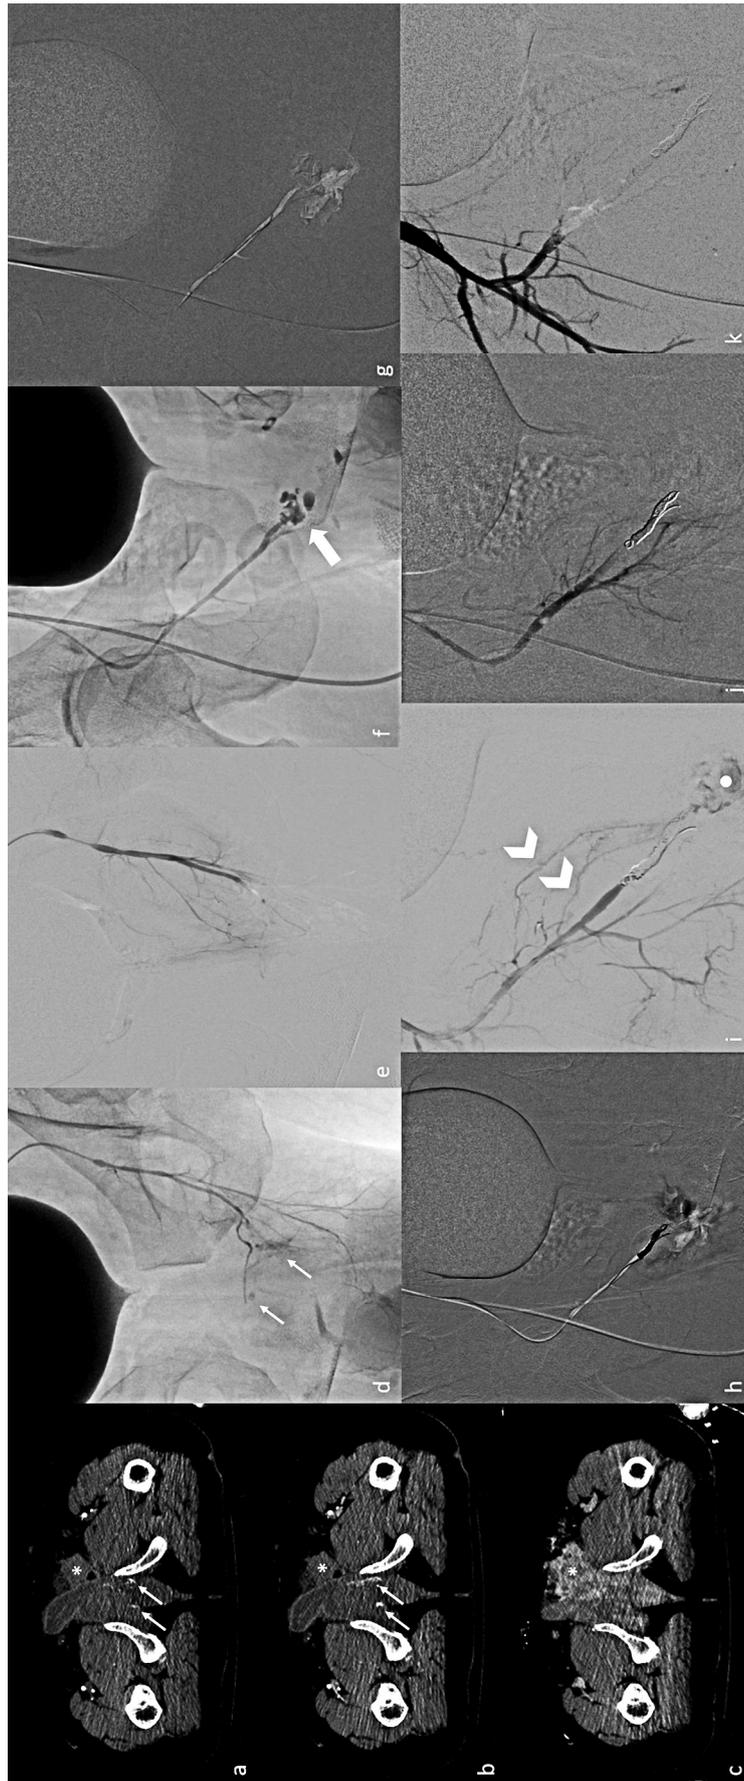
Motorcycle accident in a 46-year-old man with pelvic trauma. (a–c) CT axial images show an important left hematocoele (asterisk) supplied by two small spots of active bleeding (thin arrows) which increase during the post-contrast venous (b) and late (c) phases. (d) Left pudendal artery angiography confirms the presence of the small vascular lesions which are effectively controlled by absorbable particle embolization (e). Contralateral angiography (f) reveals a massive bleeding (thick arrows) due to an important vascular injury of the main trunk of the right pudendal artery which is managed with selective catheterization (g) and embolization (h) with 5 mm and 6 mm coils. Angiographic run after coil deployment (i) shows persistent bleeding (dot) from small collateral vessels (arrowheads) which is successfully managed (j,k) with absorbable particle embolization.
